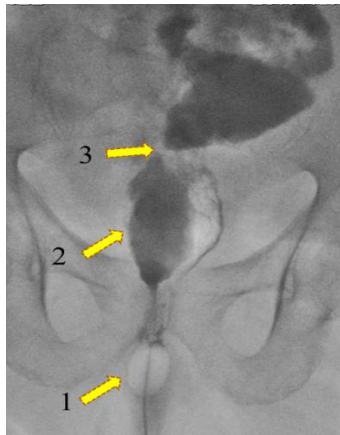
X-ray gastro-fistulography image (direct projection): 1: the inflated cuff of the Folley catheter inserted into the external opening of the fistula, 2: the cavity of the pelvic abscess, 3: the communication of the pelvic abscess with the loop of the small intestine.
